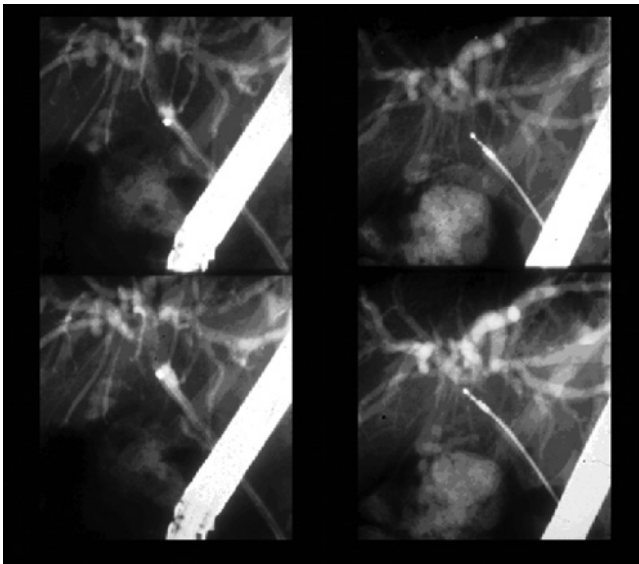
Radiologic images of intraductal ultrasound probe in the common bile duct during ERCP.
